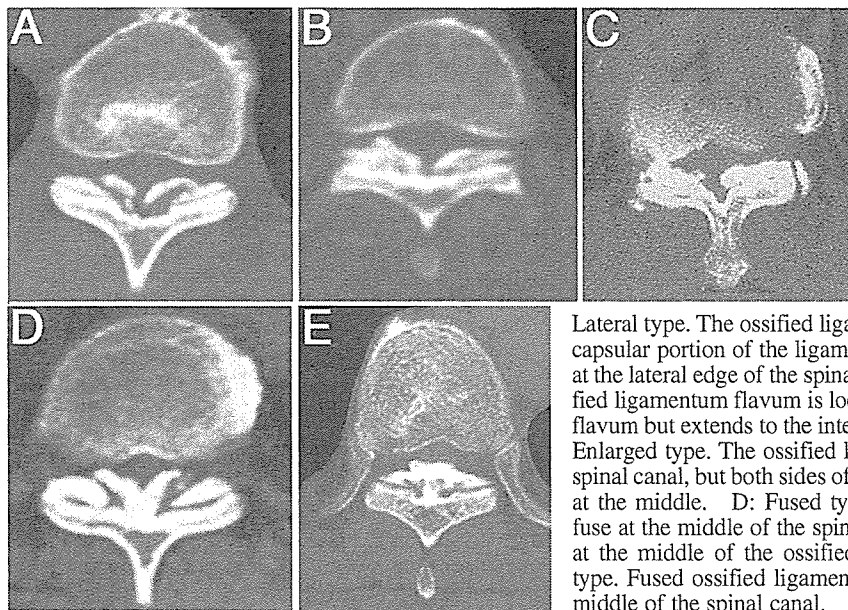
The CT classification of OLF, with scans obtained at the middle of the facet joint. A:
